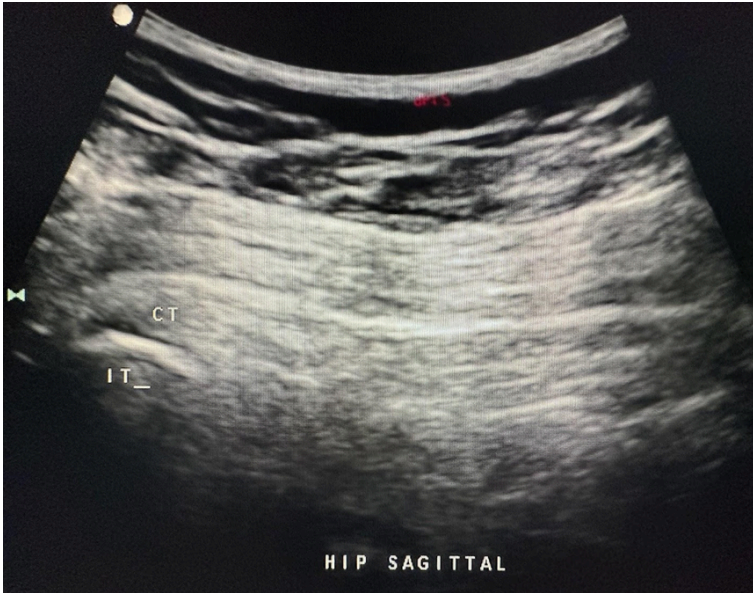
Sagittal hip image of the conjoined tendons (CT) of the biceps femoris and semitendinosus into the ischial tuberosity (IT). The abbreviations given here and labeled on the ultrasound image represent the corresponding structures.
